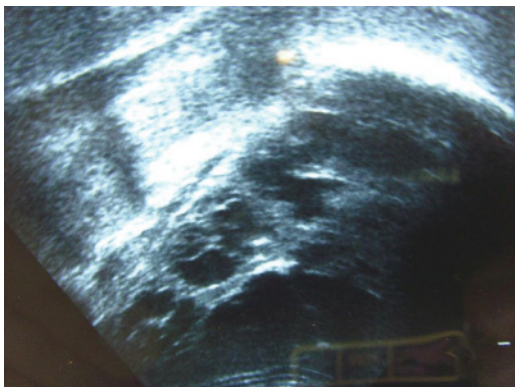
Renal ultrasound scan demonstrated multiple renal cysts.
